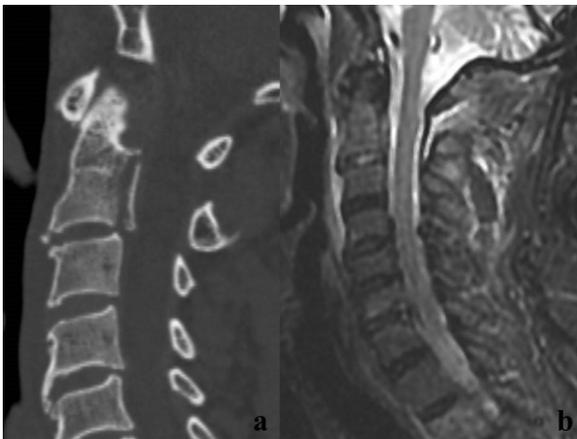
(a and b) A 62-year man hit by a car. Parasagittal reformatted CT scan (a) showing a transversal vertical fracture of posterior C2 vertebral body. Sagittal STIR-weighted MR image not depicting any signal abnormality inside C2 spongy bone. The only sign of trauma is the little hemorrhagic collection in the prevertebral space.
